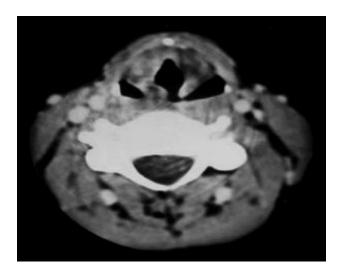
Computed tomogram of larynx showing thickening of right anterior false cord with intact cartilaginous framework.
